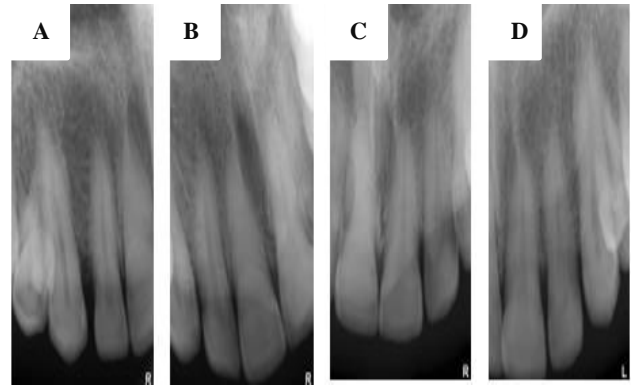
(A, B, C and D) Preapical radiograph of teeth.
